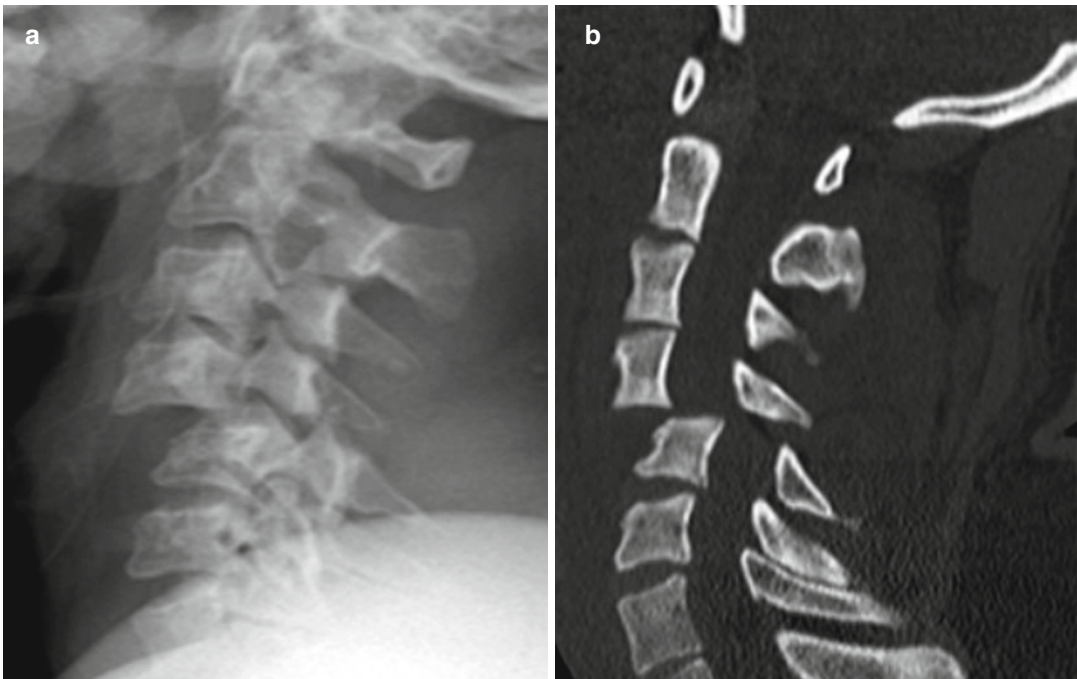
(a, b) Plain X-ray and CT show C4–C5 bilateral locked facets
